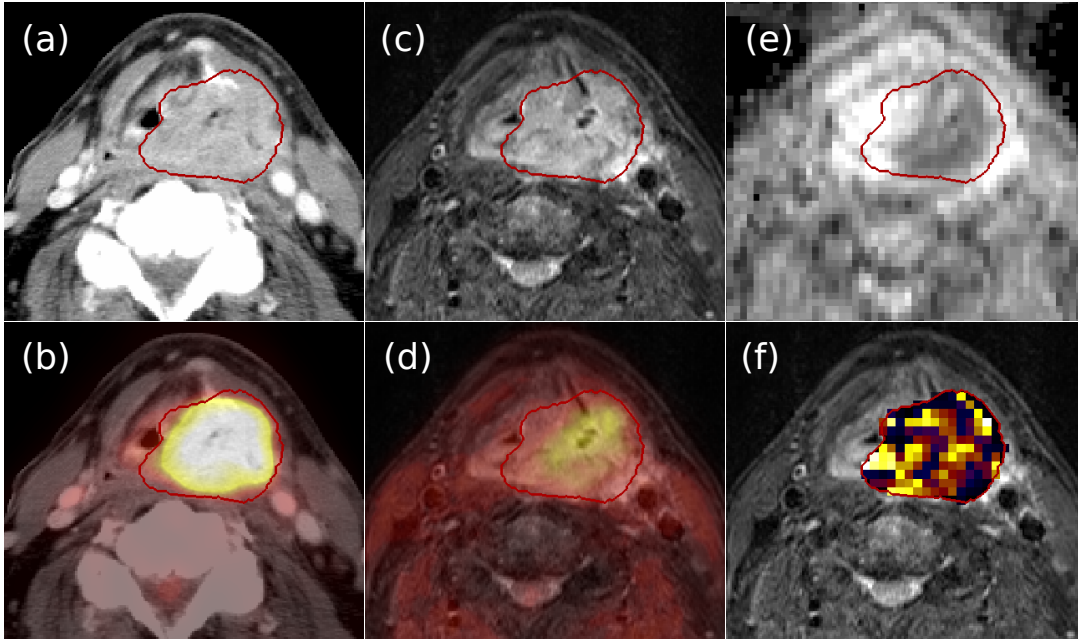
Exemplary CT-, MR-, and PET-based imaging data of a HNC patient with cancer in the hypopharynx, with GTV shown in red. Contrast-enhanced CT (a), fusion of FDG-PET and CT (b), anatomical MR (T2w STIR) (c), fusion of FMISO-PET 3 h after tracer injection and MR (d), ADC-map from DW-MR (e), K^{trans} parameter map derived from DCE-MR within the GTV (f). FDG-PET and CT were acquired in PET/CT scanner, all other datasets were acquired in integrated PET/MR scanner.
